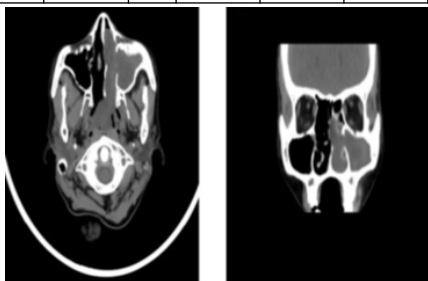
Left antrochoanal polyp: Axial and coronal CT image showing homogeneous soft tissue attenuating mass extending from antrum to choana with widening of maxillary ostium.
